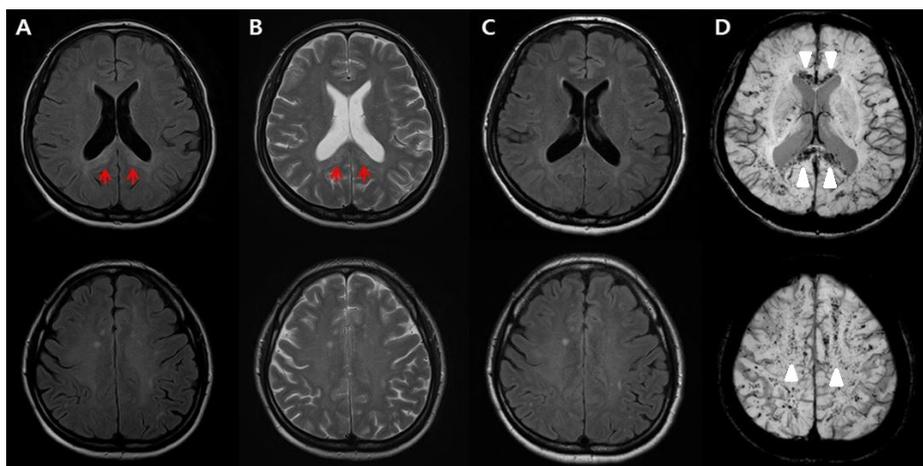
MRI at 2 weeks (A and B) and 4 weeks (C and D) after the first onset of symptoms. Fluid-attenuated inversion recovery (FLAIR) images (A) and T2-weighted images (B) showed an edematous high-signal lesion at the corpus callosum (arrows). These high signal intensity lesions disappeared on the follow-up FLAIR images (C), and multiple patchy microhemorrhages newly appeared on the susceptible-weighted images (SWI) over a diffuse area including the area of the lesion (D) (arrow heads).
